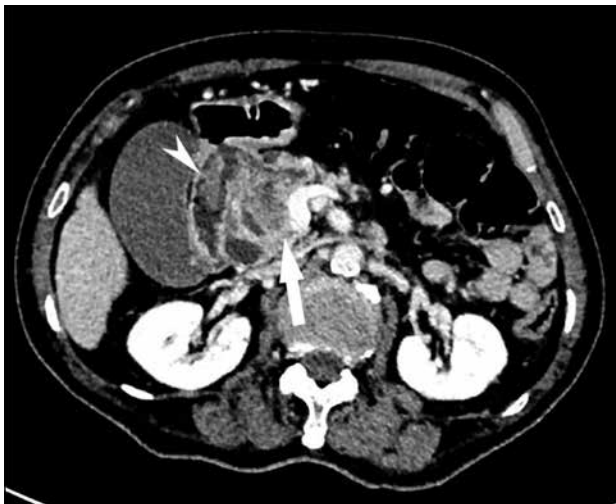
Computed tomography image of the abdomen 15 months after initial presentation showing a new irregular enhancing mass suggestive of carcinoma at the head and uncinate process of the pancreas with connection to the main pancreatic duct (arrow) and extension to the duodenum.
